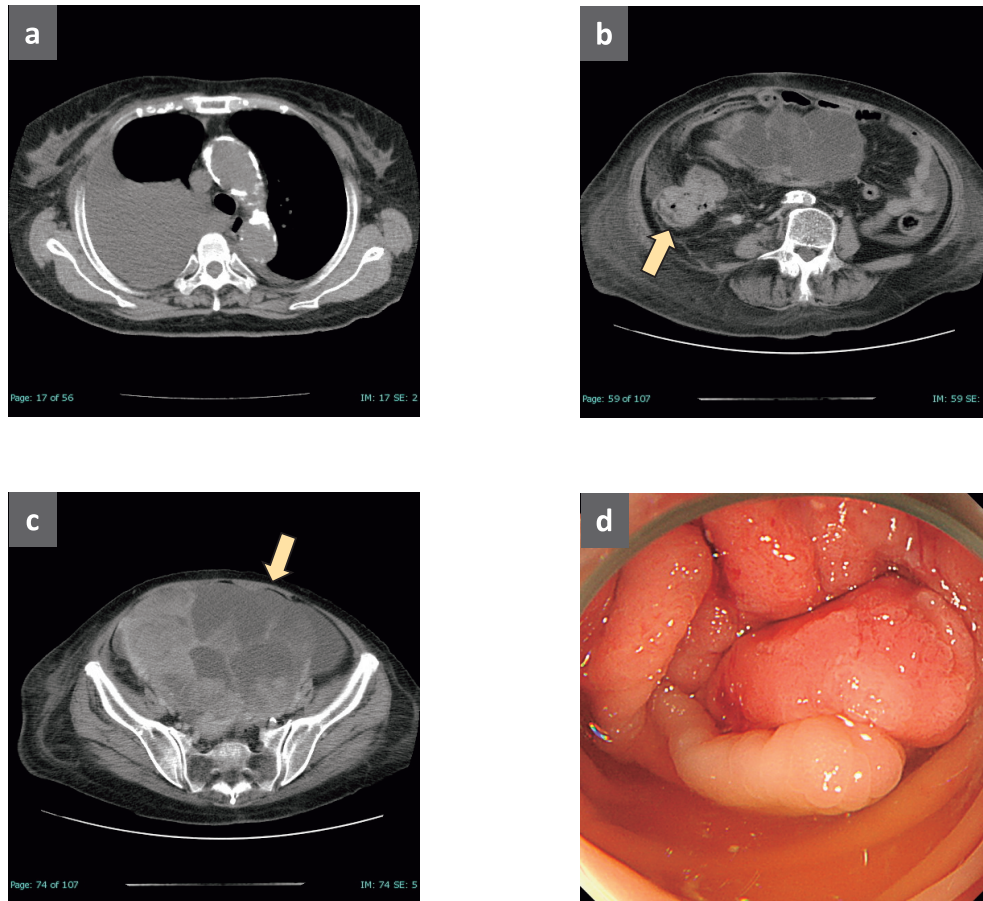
Preoperative chest and abdominal contrast-enhanced CT and colonoscopy images
